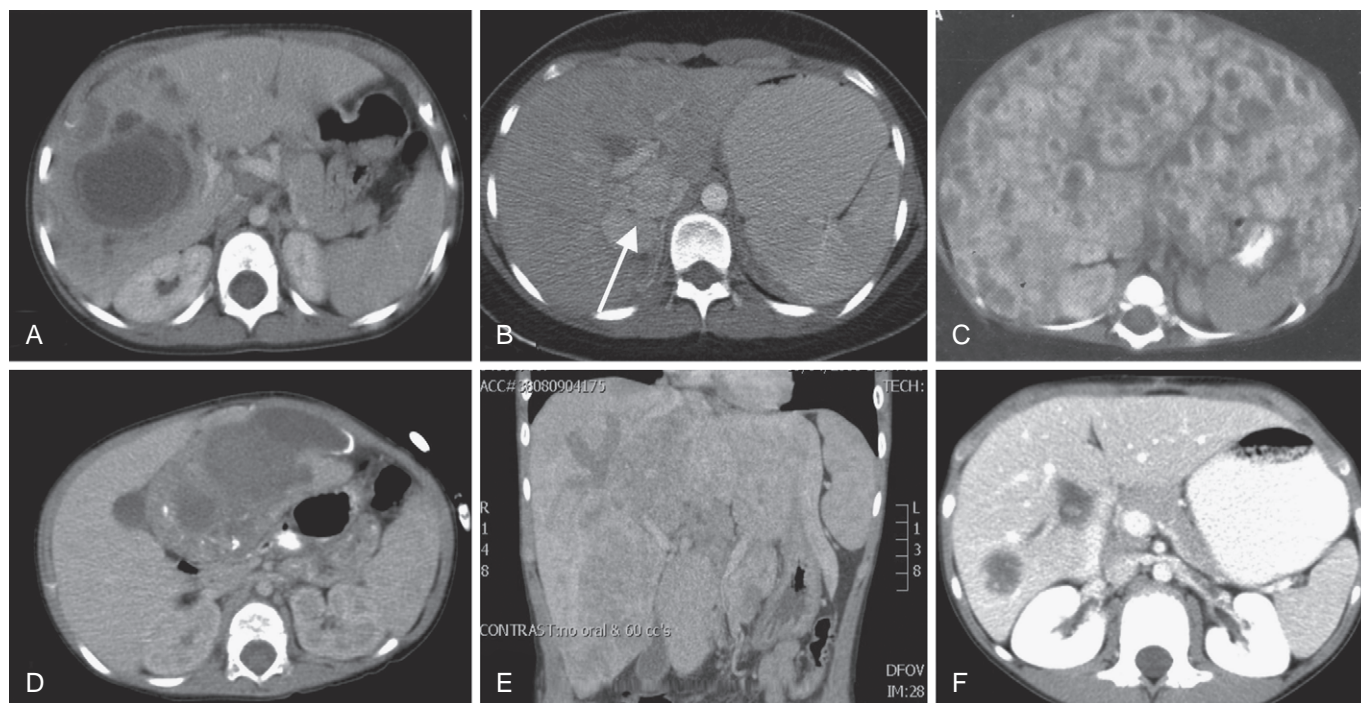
Radiographic appearance of the most common hepatic benign and malignant neoplastic masses of the liver in children. A, Mesenchymal hamartoma, a complex multicystic mass with solid septae. B, Focal nodular hyperplasia with *arrow* pointing to classic stellate central scar. C, Diffuse infantile hepatic hemangioma with multiple nodules showing peripheral contrast enhancement. D, PRETEXT 2 hepatoblastoma. E, PRETEXT 4 + P hepatocellular carcinoma with involvement of main portal vein. F, Metastatic tumor, two nodules of metastatic colorectal carcinoma in right anterior and posterior sections.
